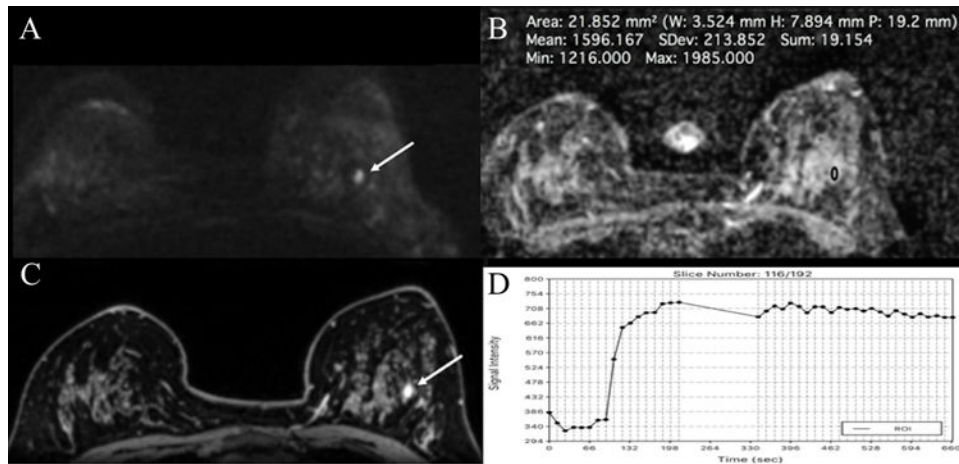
Fibroadenoma in a 42-year-old woman, centro-lateral in the left breast: (A-C) The irregular-shaped and partially irregularly marginated 7mm mass demonstrates (D) an initial fast/plateau (II) slightly heterogeneous contrast enhancement. (E) On DWI, the mass is bright on $b=850$ images due to “T2-shine through, but has (F) no decreased ADC values ($1.596 \times 10^{-3} \text{ mm}^2/\text{s}$). DCE-MRI and DWI were discordant. According to the BI-RADS-adapted reading algorithm, the BI-RADS assessment category assigned based on DCE-MRI was overruled and multiparametric MRI correctly classified the mass as benign.
